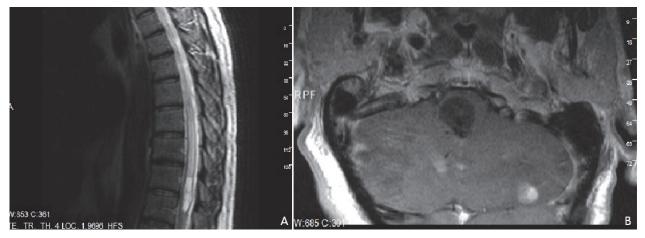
Spinal hemangioblastoma (A) T2 weighted sagital MRI images show hyperintense cystic lesion at D11-12 vertebra levels. (B) Cerebellar hemangioblastomas on T1 weighted post contrast images show hypointense cystic lesion with eccentric enhancing nodular component.
